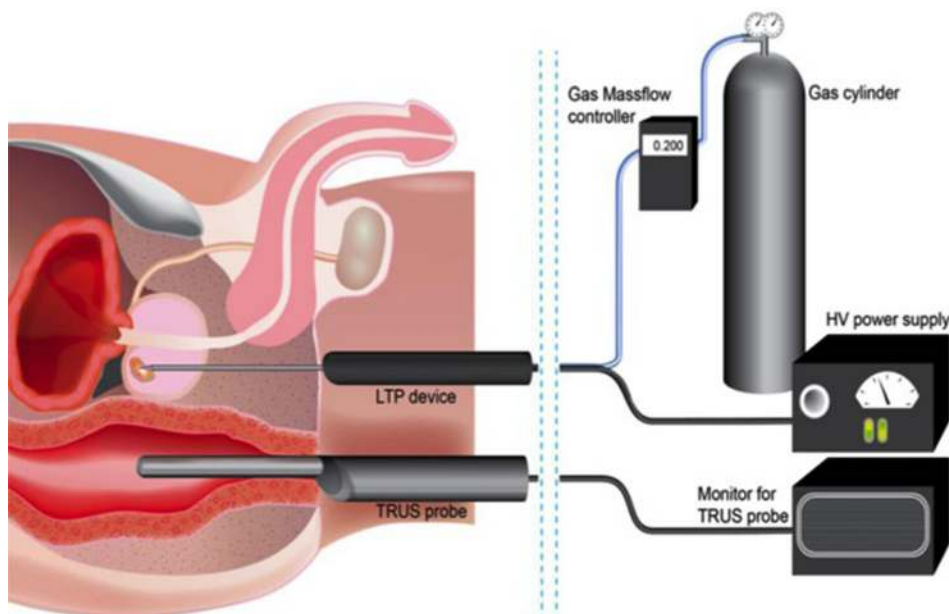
Proposed configuration for treating localized prostate tumor using a low temperature plasma (LTP) device, with positional guidance provided by ultrasound (TRUS probe) (Ref. 46).
